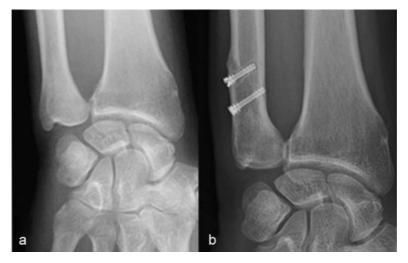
(a) Initial plain X-ray image showing a positive ulnar variance. (b) Previous ulnar shortening osteotomy.
